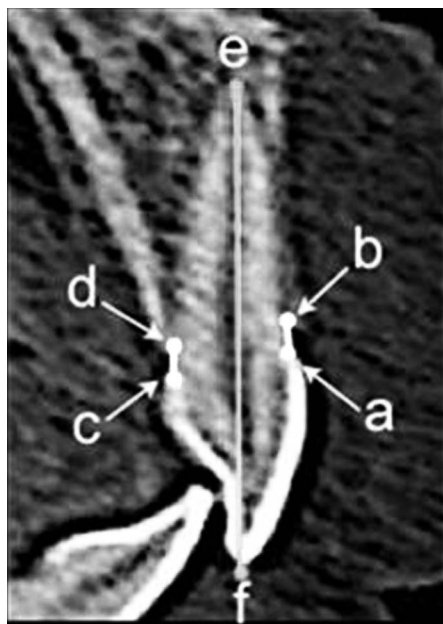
CBCT sagittal view of maxillary central incisor: distance from (a) buccal cemento-enamel junction, (b) buccal alveolar crest, distance from (c) lingual cemento-enamel junction to (d) lingual bone crest. Line = VDA of (e) root apex to (f) incisal edge.
